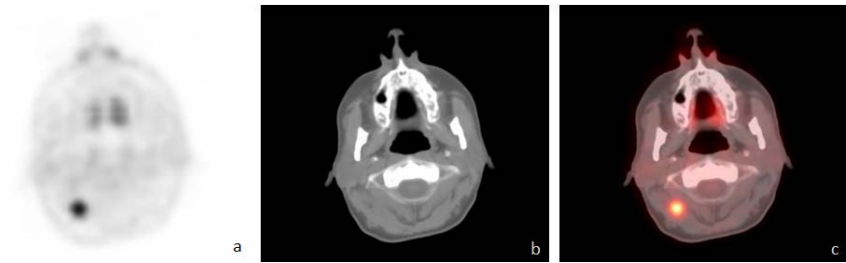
Melanoma metastasis. Figure 14a. Abnormal increase in metabolic activity is seen in the posterior right upper neck. Figure 14b. Detection of subtle metastasis can be challenging by CT. Figure 14c. Fusion of PET and CT images better identifies the anatomic structures around this metastasis. University of Massachusetts Medical School, Department of Radiology.
